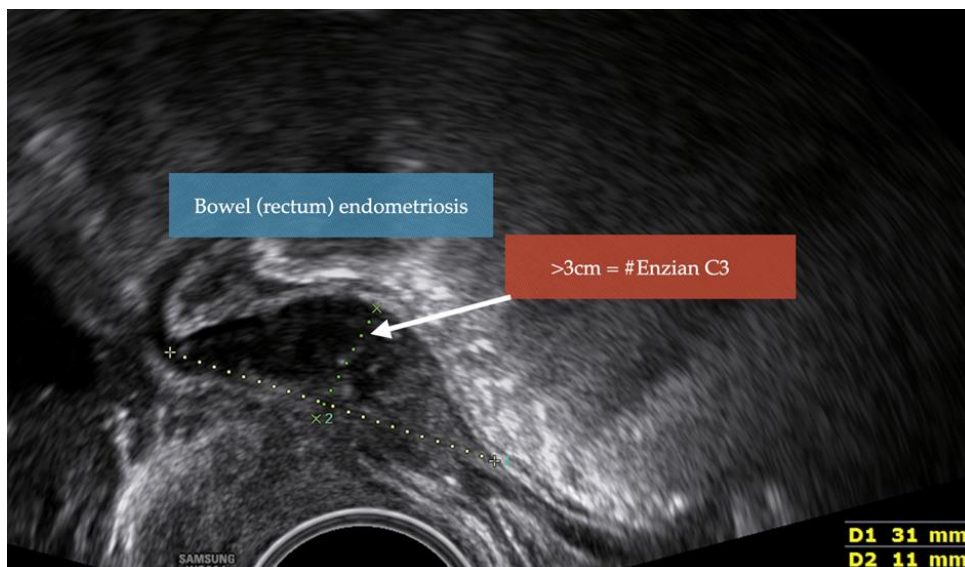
Example 1; Sonographic imaging and coding of DE of the anterior wall of the rectum, in sagittal section. The rectal wall is infiltrated by endometriosis (hypodense area represents the infiltration of the muscular layer) over a length of 3.1cm. Coding: #Enzian(u) C3.
